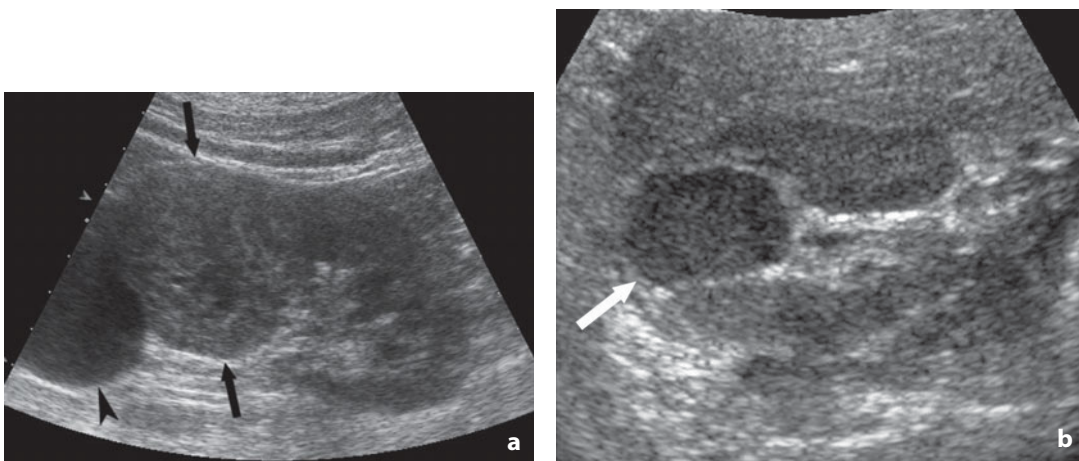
Ultrasonography. Renal cell carcinoma. a Isoechoic lesion of the left kidney (*arrows*) with a change in the normal relationship between renal cortex and sinus. Adjacent simple cysts are visible in the upper pole (*arrowhead*). b Hypoechoic solid lesion (*arrow*) with distortion of the cortical margin at the pelvic sinus
